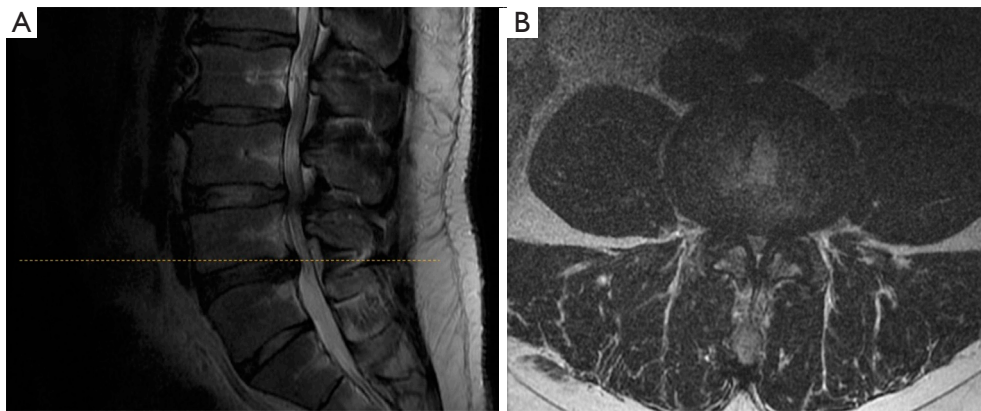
Preoperative MRI of the lumbar spine. (A) Sagittal MRI of the lumbar spine showing congenital lumbar stenosis with a narrowed spinal canal and multiple levels of the severe stenosis most notable at L2–3, L3–4, and L4–5; (B) axial MRI showing the most stenotic level, L3–4.
